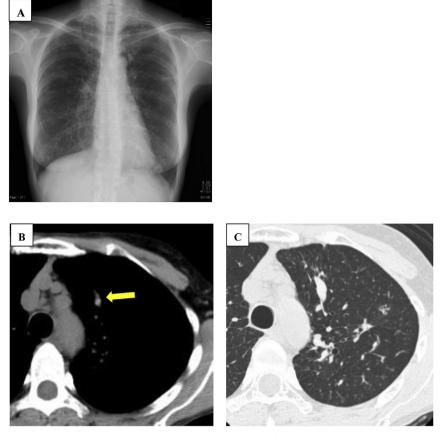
Radiological findings on admission. Chest X-ray showed bilateral bronchial wall thickening (A), and CT showed central bronchiectasis, high-attenuation mucoid impaction (arrow) (B), and centrilobular opacities and nodules (C).
